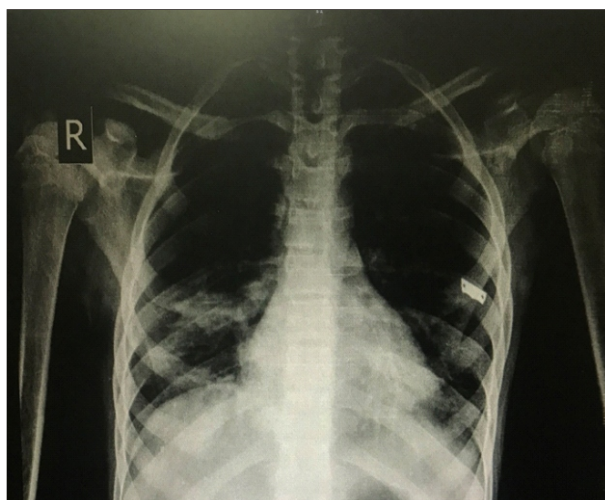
Chest x-ray before treatment suggestive of Right Lower zone cavitation
